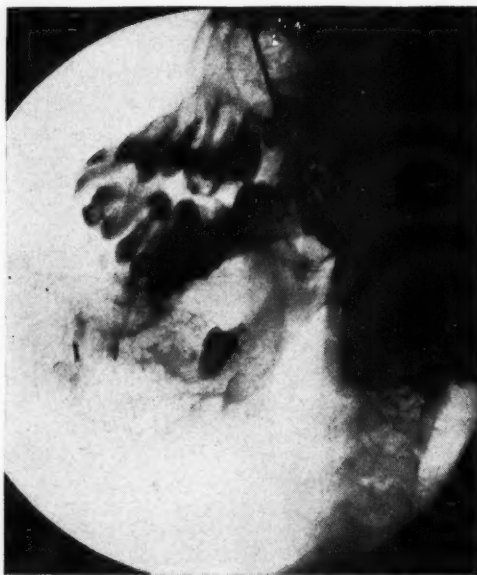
Case 6. Roentgenogram of the tumor showing it replacing the mandible and containing faint radiating bone; also two radon seeds.
